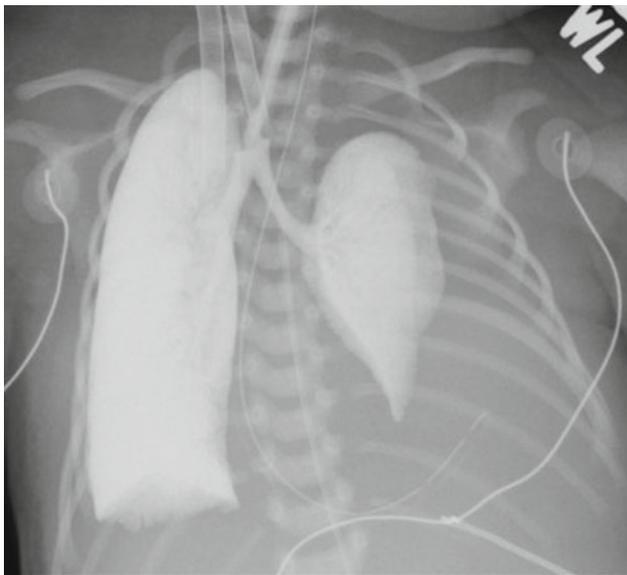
Liquid ventilation. Chest radiograph performed in newborn with left congenital diaphragmatic hernia (CDH) on ECMO and liquid ventilation. Note the presence of ECMO cannulas, NG tube tip in stomach located in the left hemithorax, ascending vascular catheter (UAC), and perflubron within trachea-bronchial tree and the lungs. The left lung is hypoplastic secondary to left side CDH
